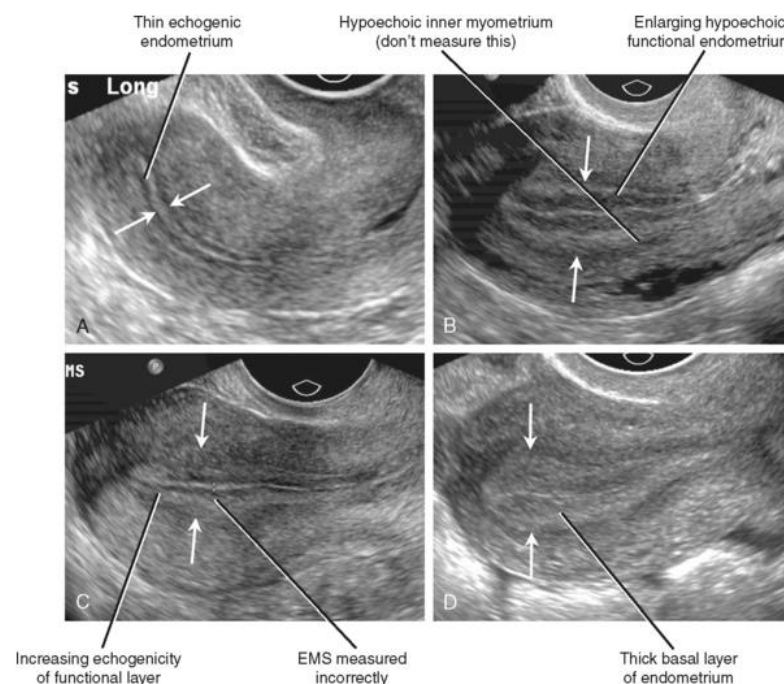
Cycle-related changes in the appearance of the endometrial stripe (EMS) on transvaginal ultrasound. A, Early proliferative endometrium. B, Late proliferative endometrium. C, Early secretory endometrium. D, Late secretory endometrium. Opposing Arrows on each image demonstrate correct cursor placement to measure thickness of the EMS. (Childs, 2016)
